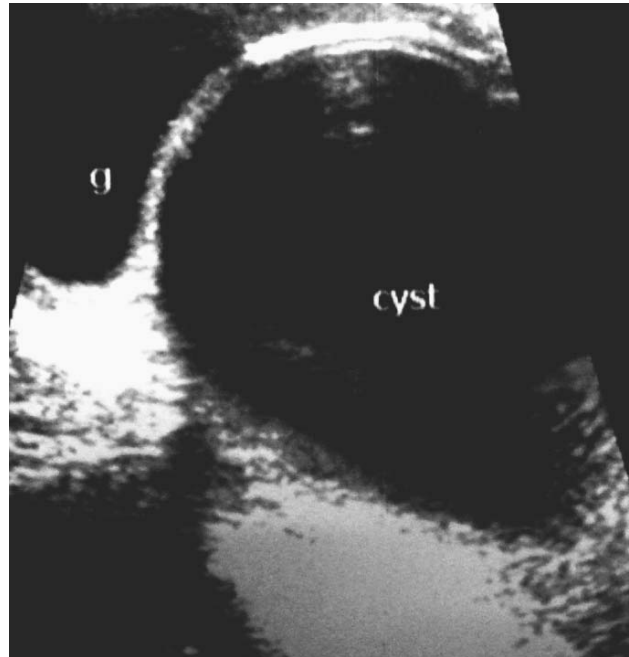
Ultrasonography of the left orbit showing cystic lesion in the retrobulbar region with displaced globe (g).
